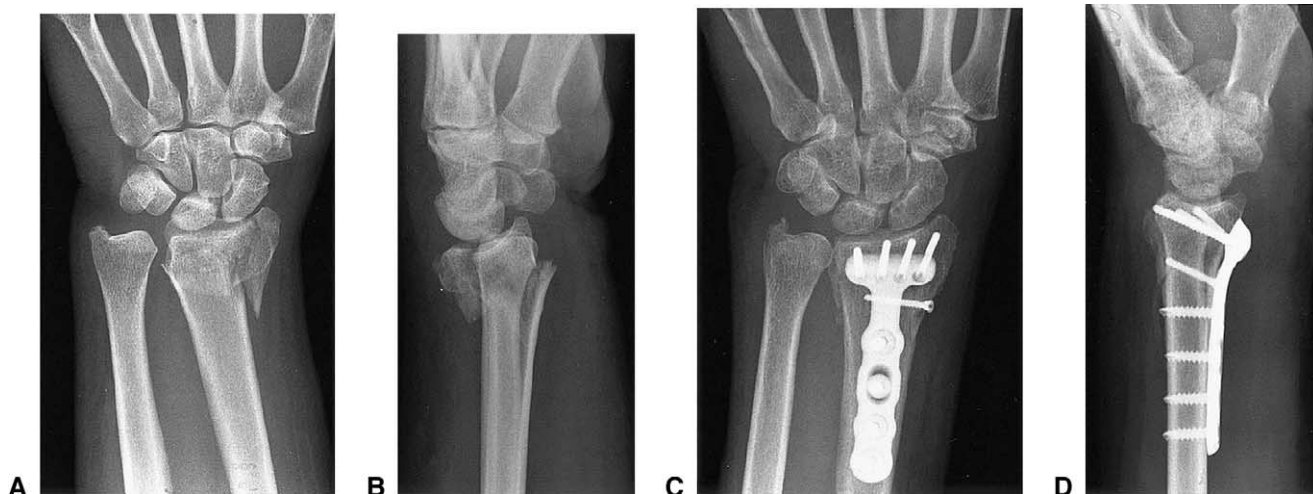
(A) Anteroposterior and (B) lateral preoperative films of a 78-year-old woman with an intra-articular, unstable distal radius fracture. Postoperative x-rays, (C) anteroposterior and (D) lateral, at 6 weeks after volar fixed-angle plate fixation showing correction of radial length, dorsal tilt, and complete fracture healing. At final evaluation (14 months) (E) wrist extension, (F) flexion, (G) supination, and (H) pronation were 50°, 53°, 90°, and 90°, respectively (patient 20, Table 1).
